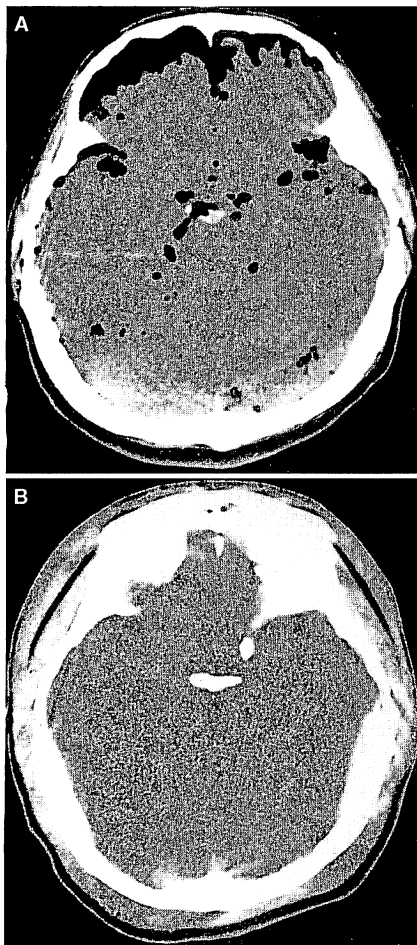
A*, computed tomographic scan at admission showing marked pneumocephalus in the subarachnoid and subdural spaces, but no brain swelling. *B*, computed tomographic scan on Day 6 showing diffuse brain swelling and bitemporal thin epidural hematomas.
